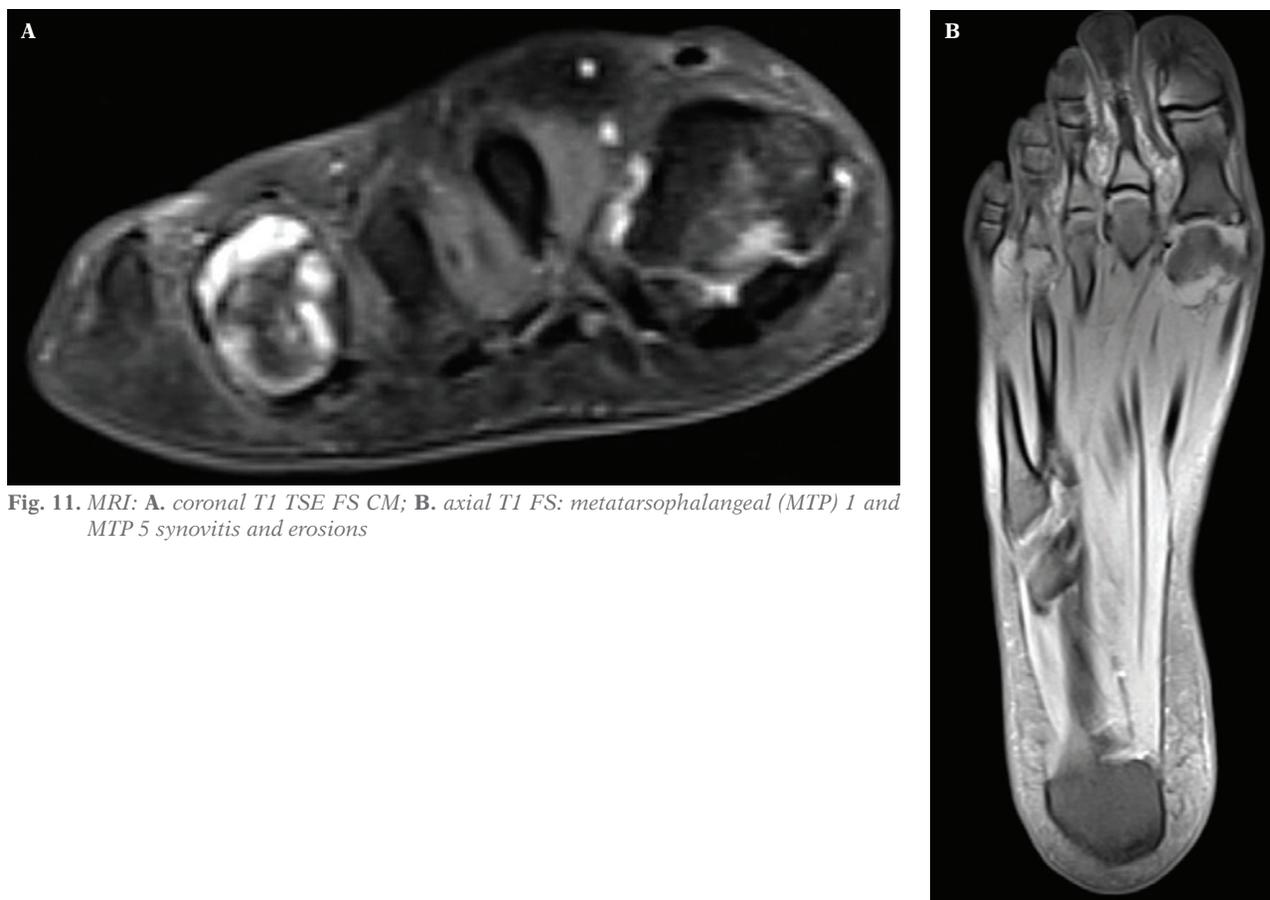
MRI: A. coronal T1 TSE FS CM; B. axial T1 FS: metatarsophalangeal (MTP) 1 and MTP 5 synovitis and erosions
